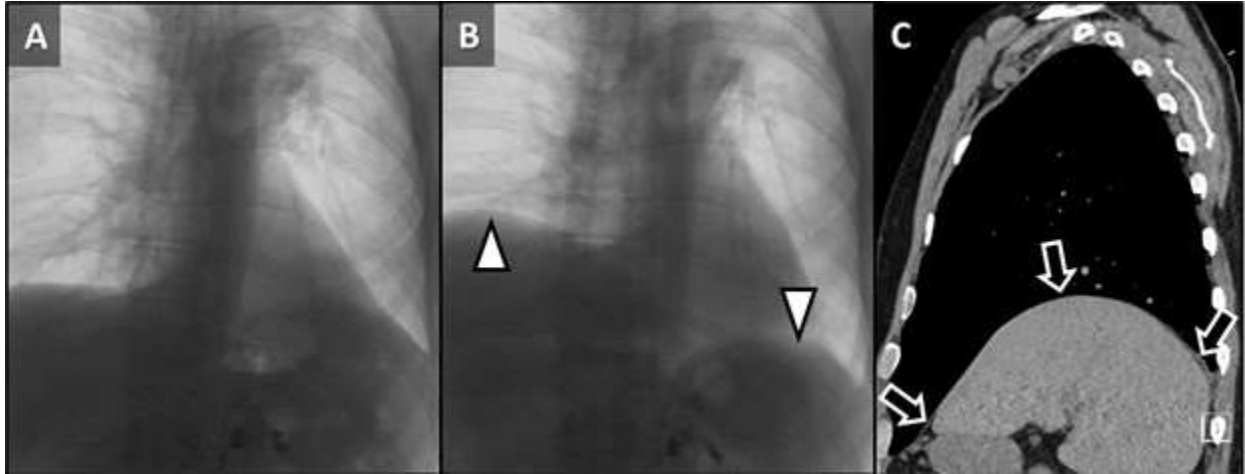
Fluoroscopic images from a sniff test at end tidal (A) and “sniffing” (B) portions of exam demonstrating normal depression of the left hemidiaphragm (down arrowhead) and paradoxical elevation of the right hemidiaphragm (up arrowhead) consistent with right hemidiaphragmatic paralysis. Sagittal reconstruction from a noncontrast chest CT (C) demonstrating an elevated but otherwise normal appearing right hemidiaphragm (arrows). (To view Figure 3 in a separate, enlarged window click [here](#)).
